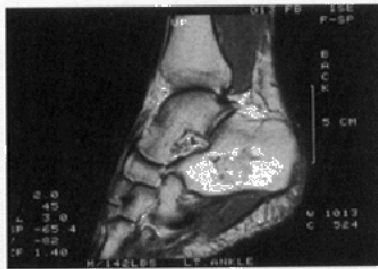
MRI at 2-years postoperative reveals complete incorporation of graft, Case 3.
